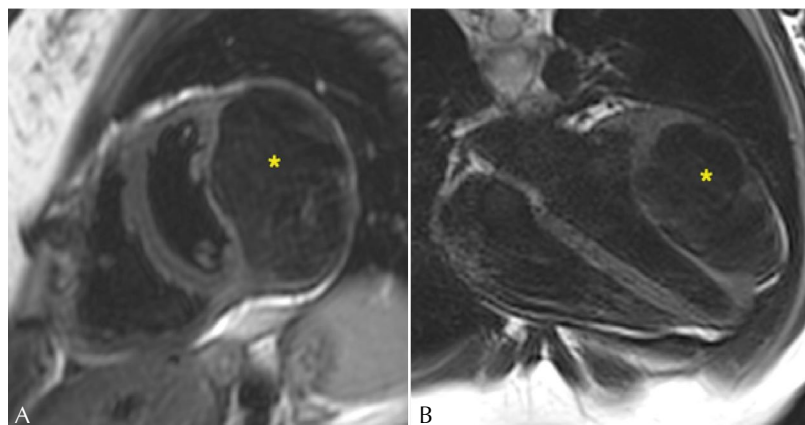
Short-axis (A) and four-chamber (B) section showing a hypointense intramyocardial mass (*) on T2-weighted cardiac magnetic resonance. Follow-up images from 2016 (A) and 2020 (B).
